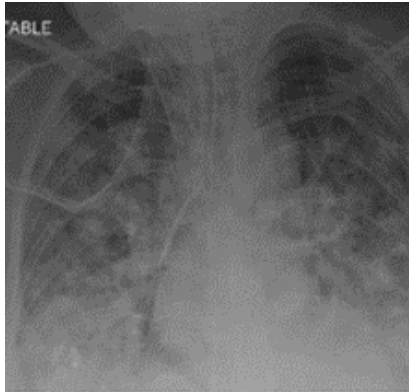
Chest radiograph showing marked progress in bilateral consolidation opacities. Aspergillus complex isolated from respiratory tract samples was obtained by non-bronchoscopic endotracheal
